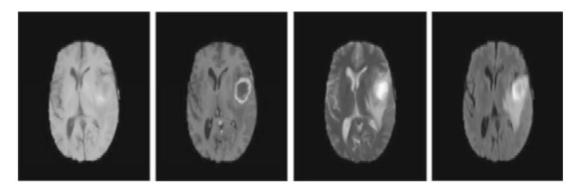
2: Different modalities with tumors present in them (Adapted from [6]). From left: T1 weighted image, T1c weighted image, T2 weighted image, and FLAIR image. These are obtained using BRATS 2013 dataset
